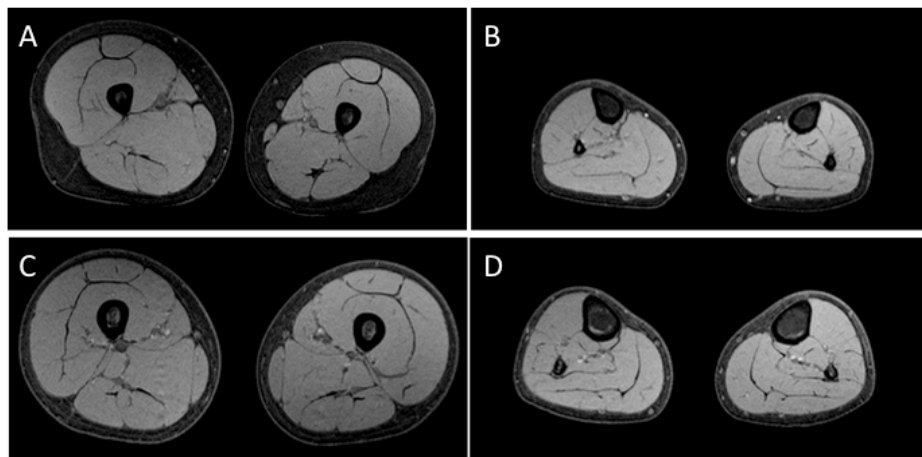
Example MRI transverse images of the thigh (a and c) and shank (b and d) muscles of a CP and an age and sex matched TD subject respectively
